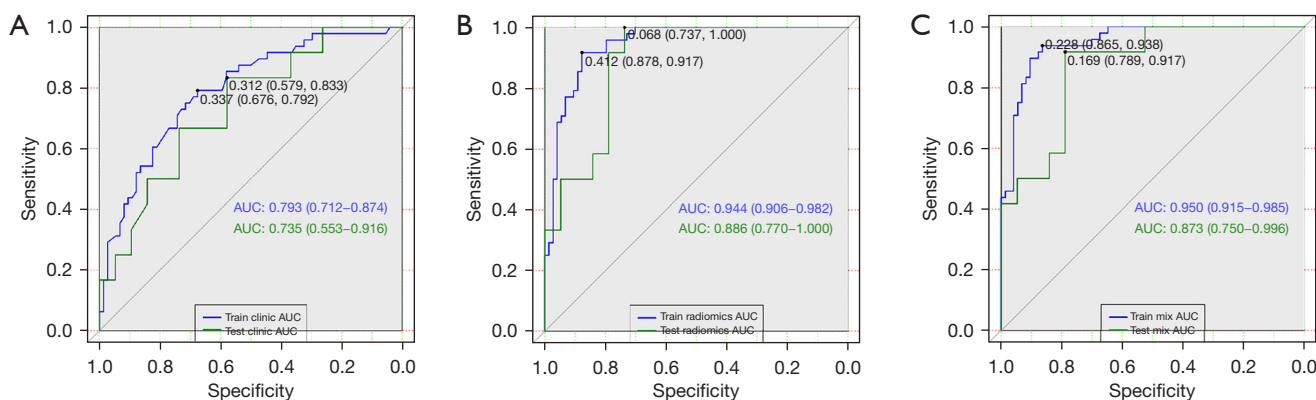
Receiver operating characteristic curves for differentiating SDPLA and IPM diseases based on three models. The area under the curve (AUC) of the clinical-CT showed t 0.793 and 0.735 in the training and testing cohort (A). The radiomics model achieved excellent performance with AUCs of 0.944 and 0.886 in the training and testing cohort (B). The MixMode showed AUCs of 0.950 and 0.873 in the training and testing cohorts (C). SDPLA, synchronous double primary lung adenocarcinoma; IPM, intrapulmonary metastasis.
